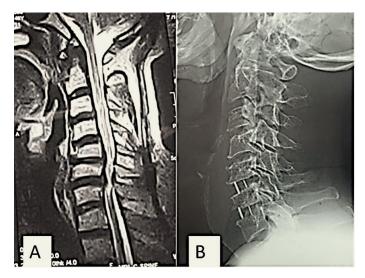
A case of double-level anterior cervical discectomy and fusion. A; preoperative MRI T2WI sagittal views on the cervical spine show disc prolapse at C5-6 and C6-7, with canal stenosis and cord compression. B; postoperative lateral cervical spine X-ray demonstrating proper positioning of the two cervical cages.
